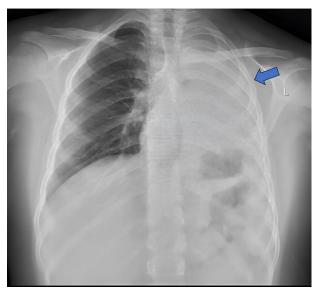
Chest X-ray revealed consolidation on the left side of the chest.
